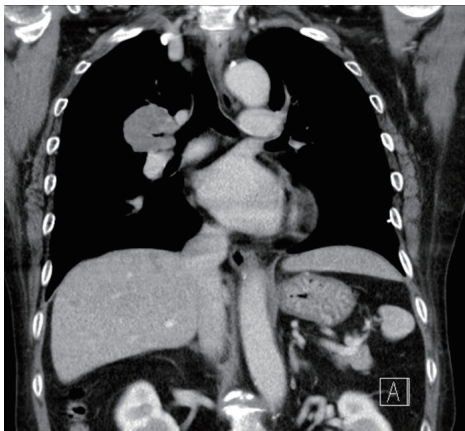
A rapidly progressed lung mass (arrow) in chest CT 6 months later.
